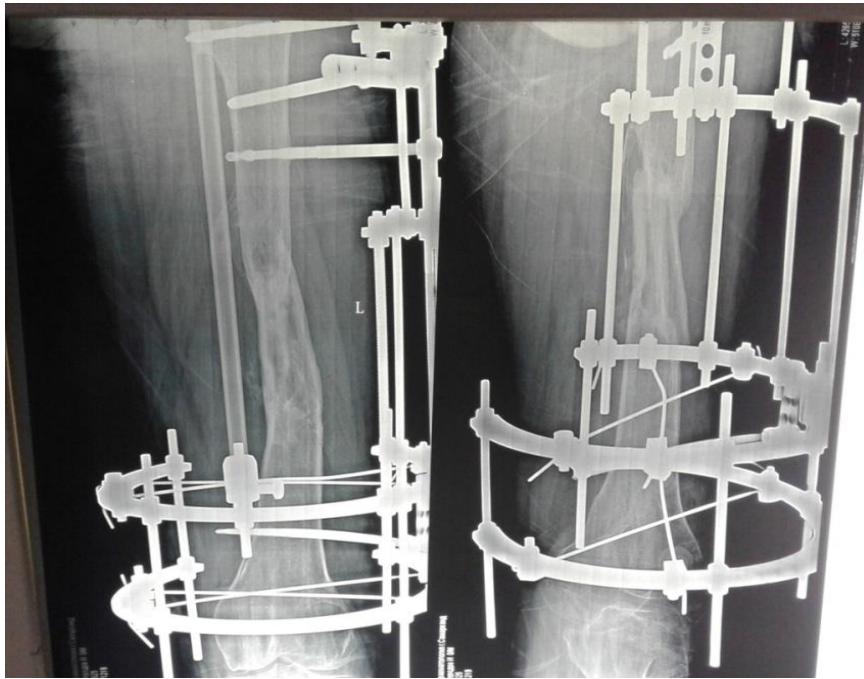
3.A patient. Control X-ray of the left femur, 12 months after surgery.
